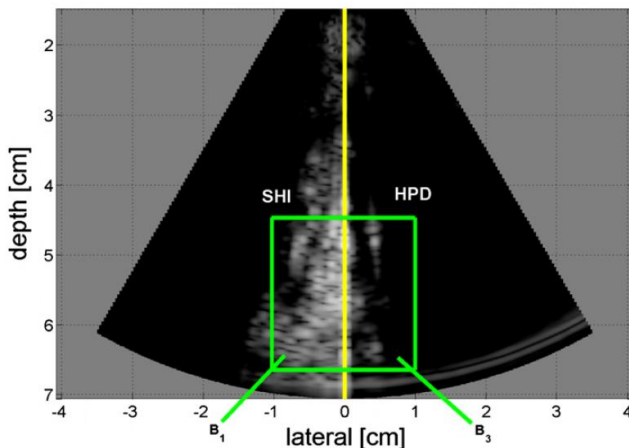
Comparison between second harmonic inversion and harmonic power Doppler.
